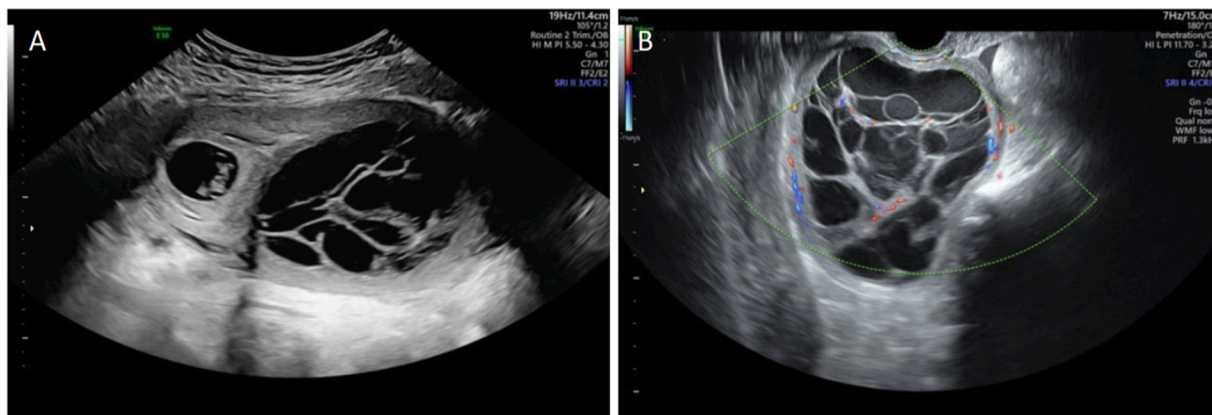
Transvaginal ultrasound demonstrating an IUP within the uterine cavity and multiseptated mass (A) with thick septations and internal color flow (B).
